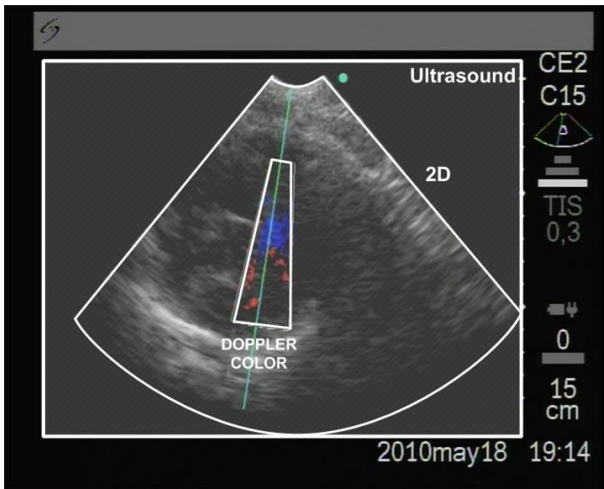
Parts of the ultrasound in the 2D modes.
